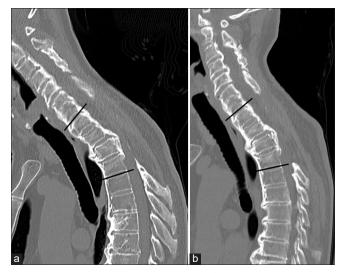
Dynamic CT sagittal image before revision surgery. CT sagittal images of forward and backward bending at the time of symptom recurrence. At the neutral position, the T1-4 kyphosis angle was 29.5° and OPLL thickness was 11.6 mm. Mobility was noted at the upper thoracic spine, which appeared to be fused. Dynamic T1-4 kyphosis angles were (a) 33.2° in forward bending and (b) 22.7° in backward bending. CT: Computed tomography, OPLL: Ossification of the posterior longitudinal ligament.
